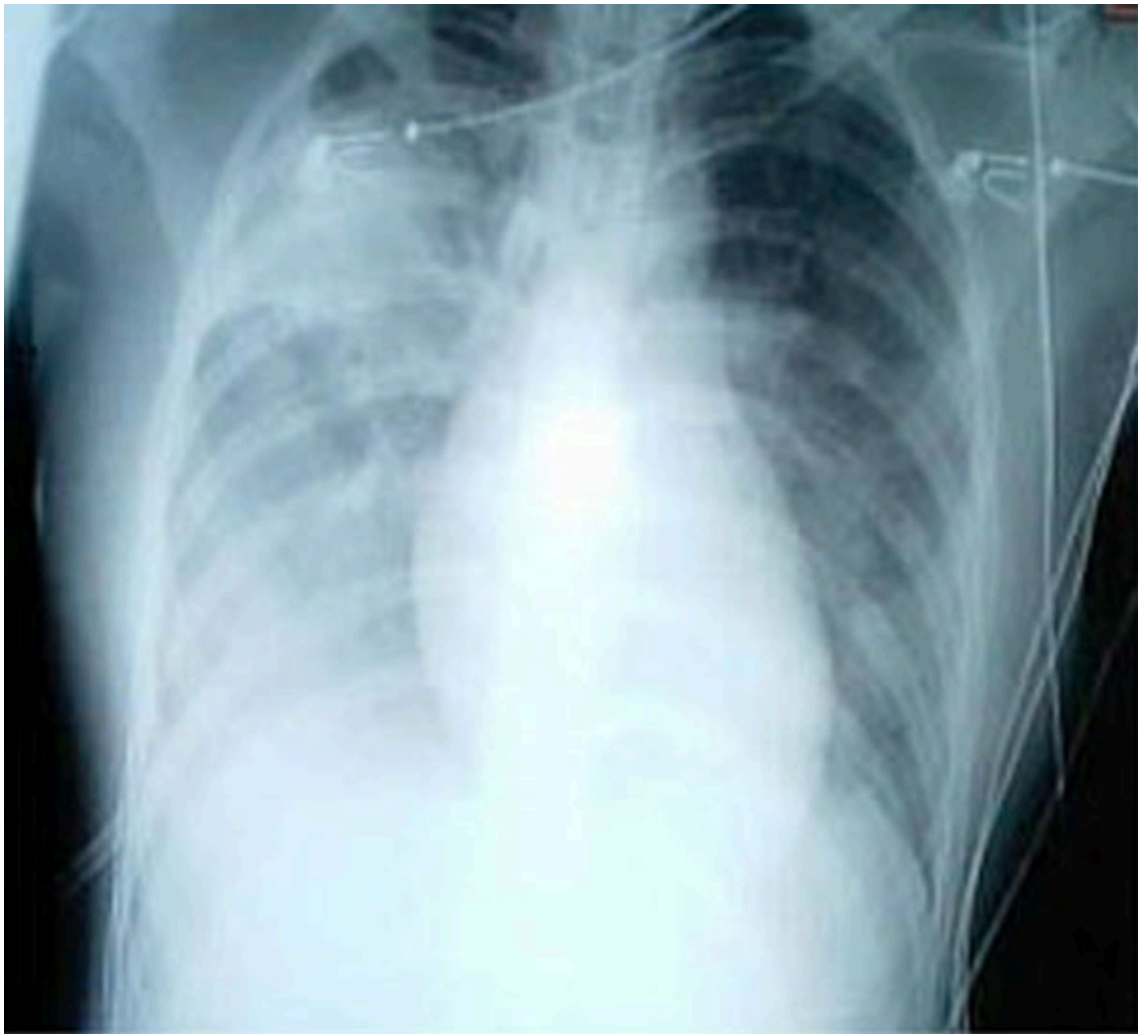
This x-ray shows bilateral infiltrates on both lungs. A ventilator-induced lung injury could appear similar to this. Photo by CDC, Public Domain
